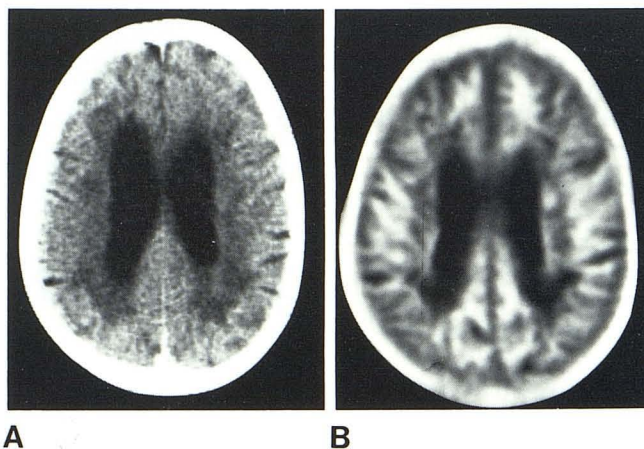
Binswanger disease. A, CT. B, IR_{1400/400}. Extensive white matter involvement seen on both scans.
